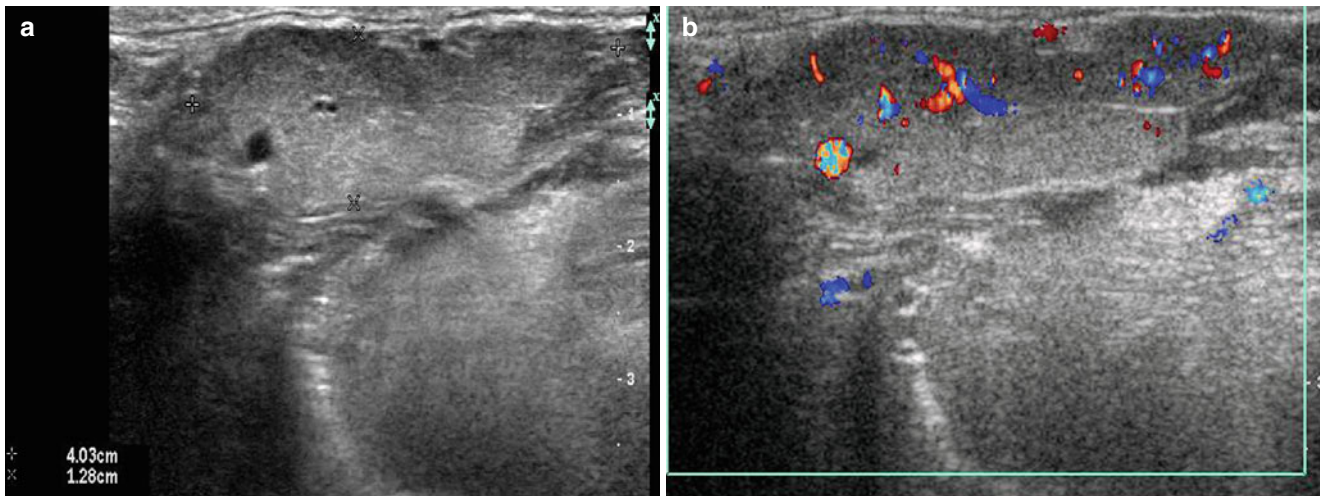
(a, b) Sialadenitis. (a) Grey scale ultrasound image (transverse view) shows diffuse enlargement of the right submandibular gland. (b) Color Doppler ultrasound image (transverse view) demonstrates increased vascularity within the submandibular gland
